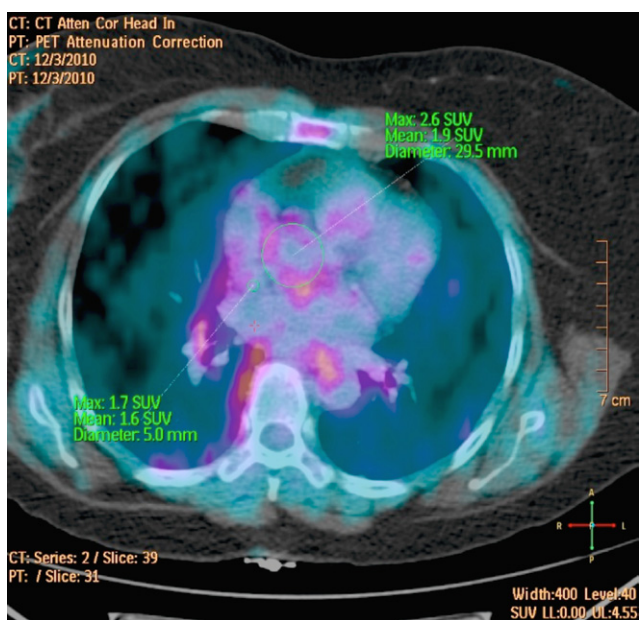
Sample FDG-PET/CT image from a long-standing RA patient with high FDG uptake in the thoracic aorta. (Color version of figure is available online.)
